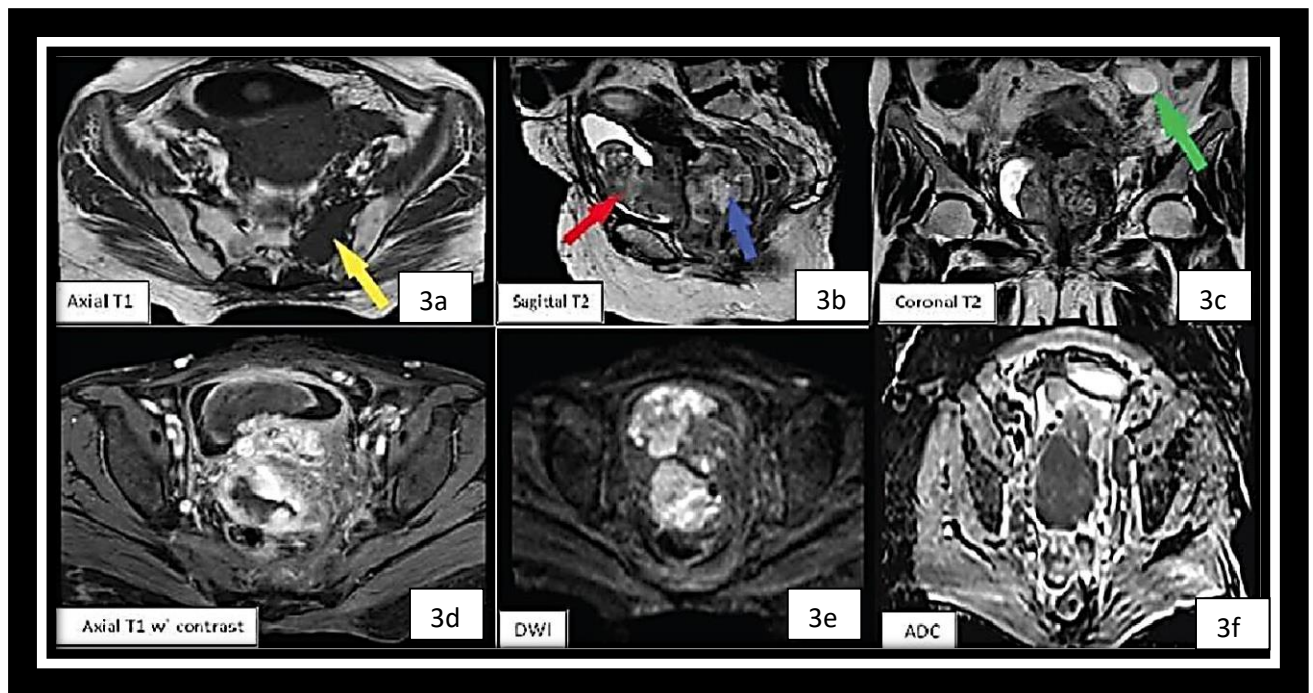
A case of Carcinoma Cervix stage IVB in different views and sequences of MRI.
